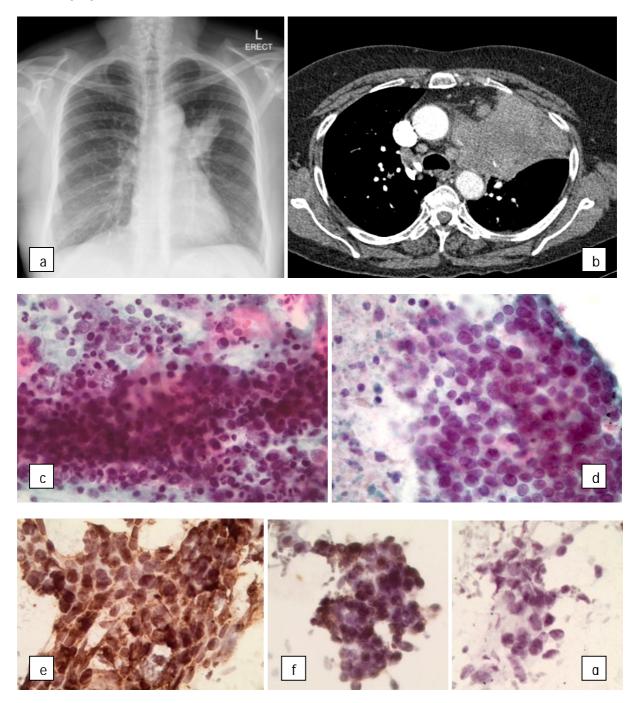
Large left perihilar mass with multiple pleural based and pulmonary nodules and lymphadenopathy on chest X-ray (a) and CT (b). Sputum - malignant. Small, poorly differentiated cells with high N/C ratio's (c). TTNA - Adenocarcinoma with neuroendocrine differentiation (d) confirmed with immunocytochemistry: strong BerEP4 positivity (e) and Synaptophysin positivity (f) while CK5 was negative (g).
